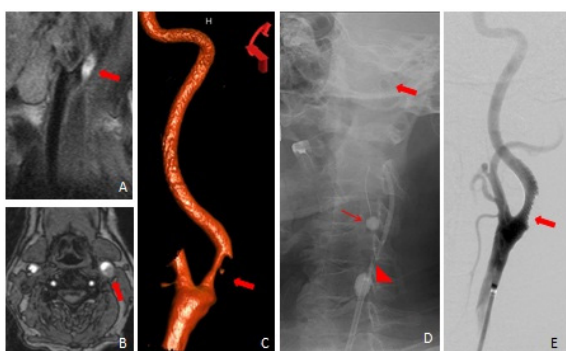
A. Plaque in T1 sagittal MRI image (arrow). B. Plaque in TOF axial MRI image (arrow). C. ICA stenosis showed by 3D angiography (arrow). D. Lateral unsubtracted angiographic view during angioplasty using dual protection with flow reversal: CCA (arrowhead) and ECA (small arrow) occluded with balloon and distal filter (big arrow). E. CCA angiography after stenting.
